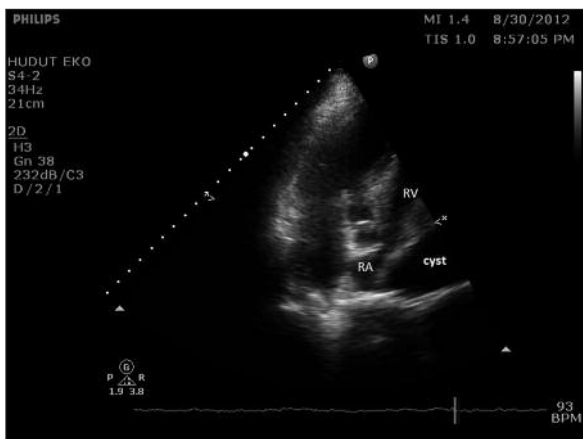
Transthoracic echocardiography (TTE) examination a large cystic lesion adjacent of the right atria.
